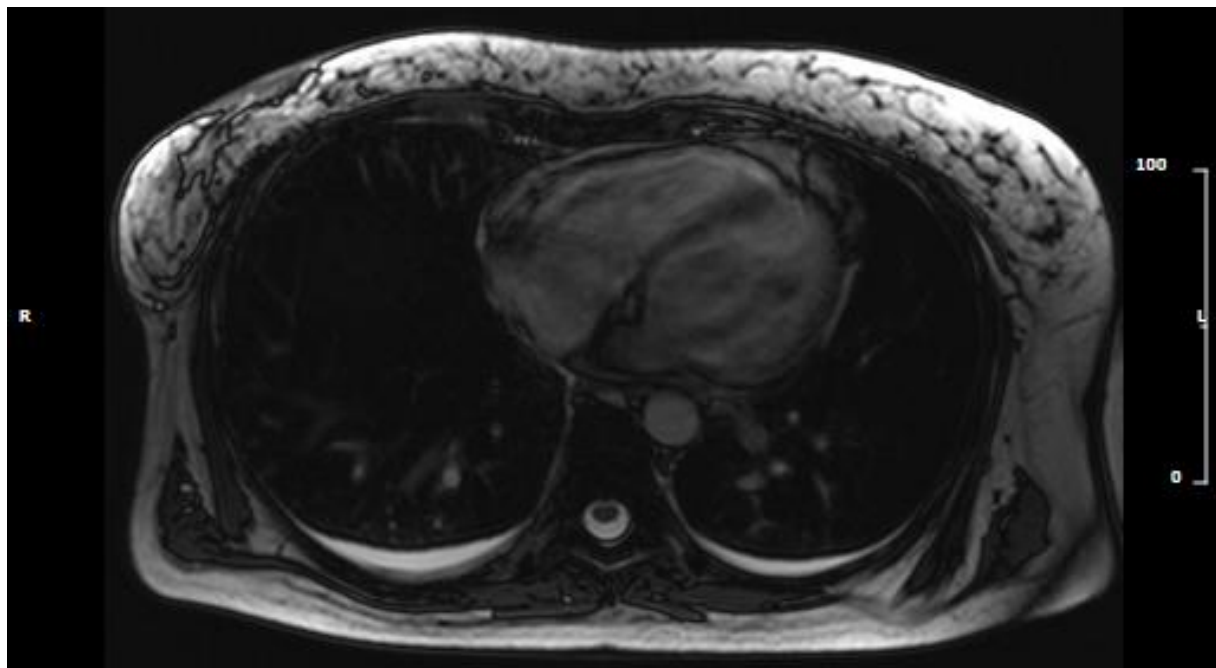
T2-weighted localizer axial image of a study patient showing hyperintense areas located posteriorly and at a basal level of the lungs, representing pleural effusions.
